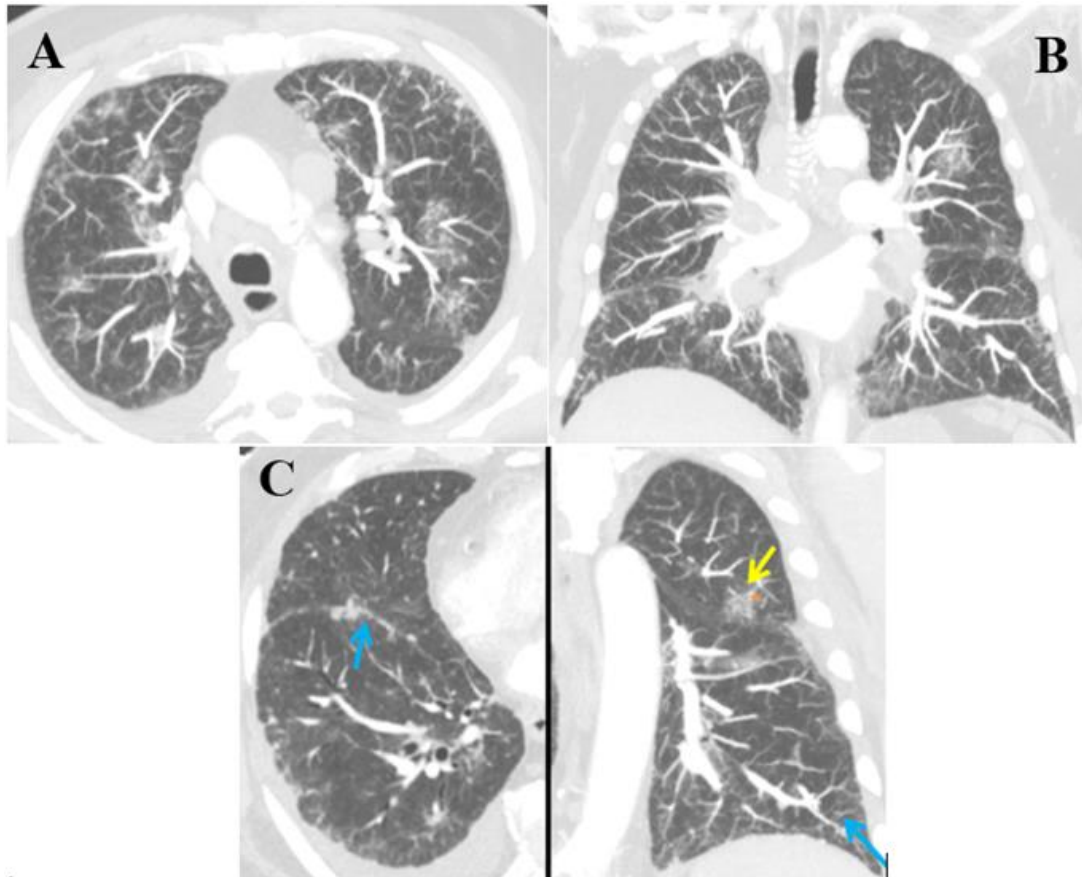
(A and B): Thoracic Angio-CT. Subpleural and centrilobulillar nodules of peri-vascular distribution associated with multifocal opacities with diffuse distribution in the bilateral lung parenchyma. Findings in relation to fat embolism, given the clinical context of the patient. (C): Thoracic CT-angiography. Blue arrows: In the axial plane micronodular thickening of the fissure. In the coronal plane thickening of the inter and intralobular septal interstitium, predominantly peripheral and basal. Yellow arrow: Focal opacity, density of tarnished glass. Centrilobulillar and perivascular nodules are seen in millimeters that are part of the opacity.
